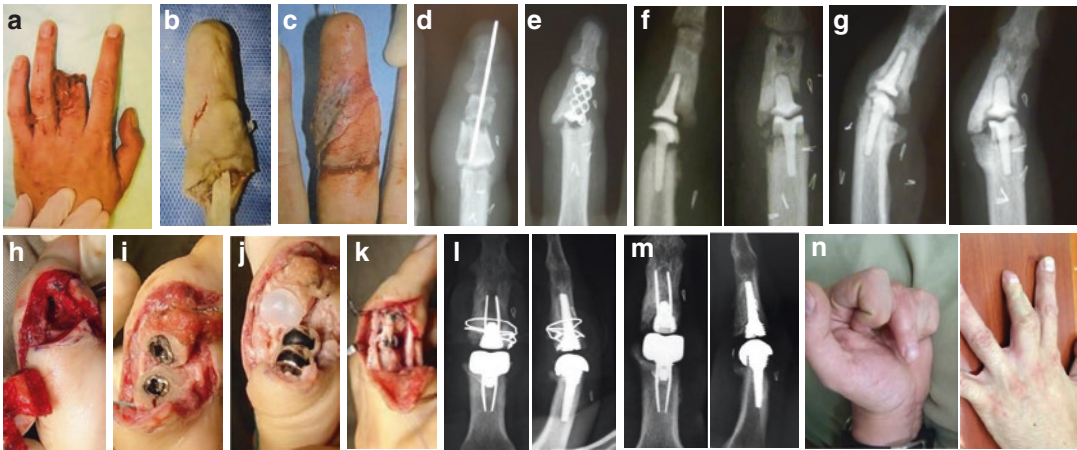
Case 4: 37-year-old male Hong Kong professional pilot had injury of his left middle finger during motor car rally competition in an overseas country in May 2005. His middle finger sustained an avulsion amputation at the level of middle phalanx with open dislocation of PIPJ. Microsurgical replantation with axial K wire fixation and skin graft was successful at Malaysia (a–d). However, it was complicated by nonunion of the middle phalanx. Revision plating and bone graft was performed in August 2005. The fracture healed, but there was progressive DIPJ fusion and PIPJ destruction, likely due to septic cause (e). Infection was treated vigorously, and finally a PIPJ arthroplasty with pyrocarbon implant was performed in August 2006 (f). All the treatments were given overseas. He returned to Hong Kong and resumed his duty initially. However, he noted a progressive radial deviation deformity of the middle finger with weakness and pain, which interfered his pilot work: x-ray showed aseptic loosening and implant displacement, associated with marked bone loss at the base of radial side of the middle phalanx post arthroplasty (g). A block of iliac bone graft was performed with periosteum attached (h).
